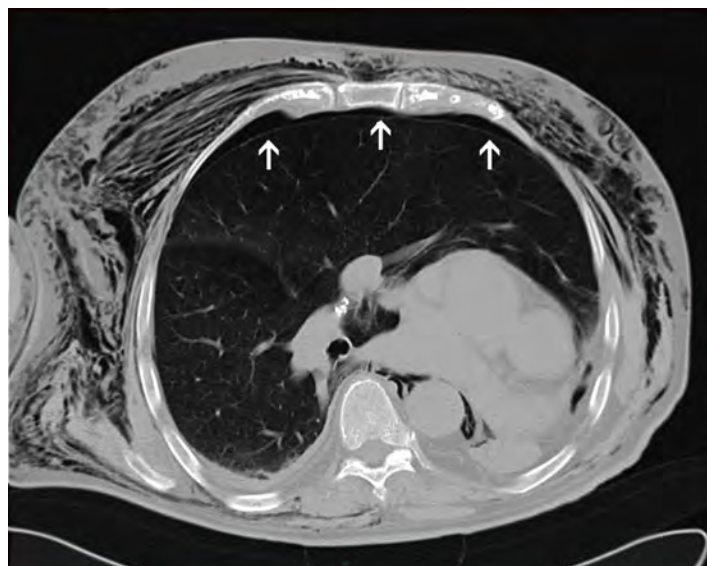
Cross-sectional computed tomography image of the pneumothorax
